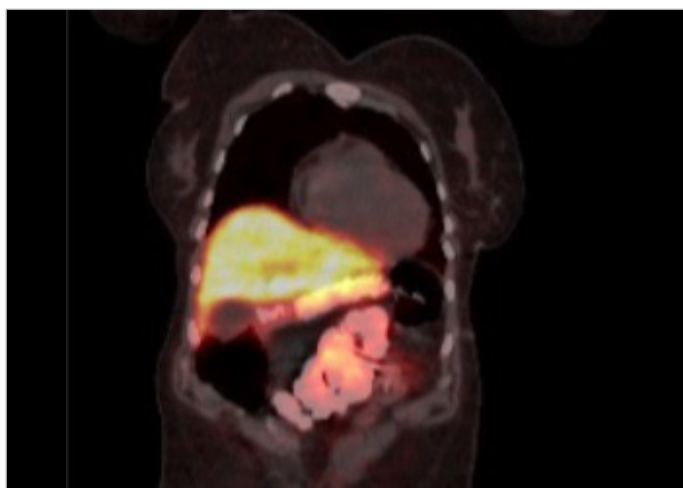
Mass lesion observed at the pancreatic body/tail junction (SUVmax: 66).
